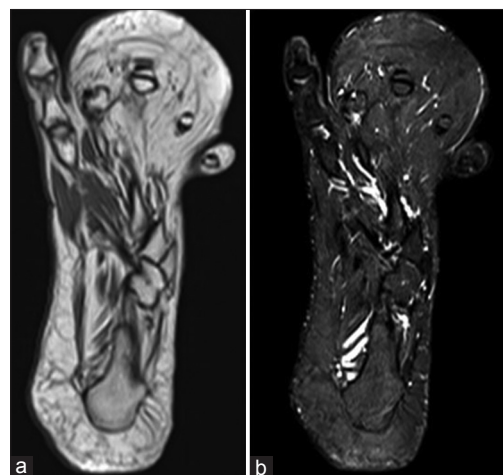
Coronal magnetic resonance images demonstrating enlargement and marked proliferation of adipose tissue characterized by high signal on T1-weighted image (a) and signal suppression on fat-saturated T2-weighted image (b)
